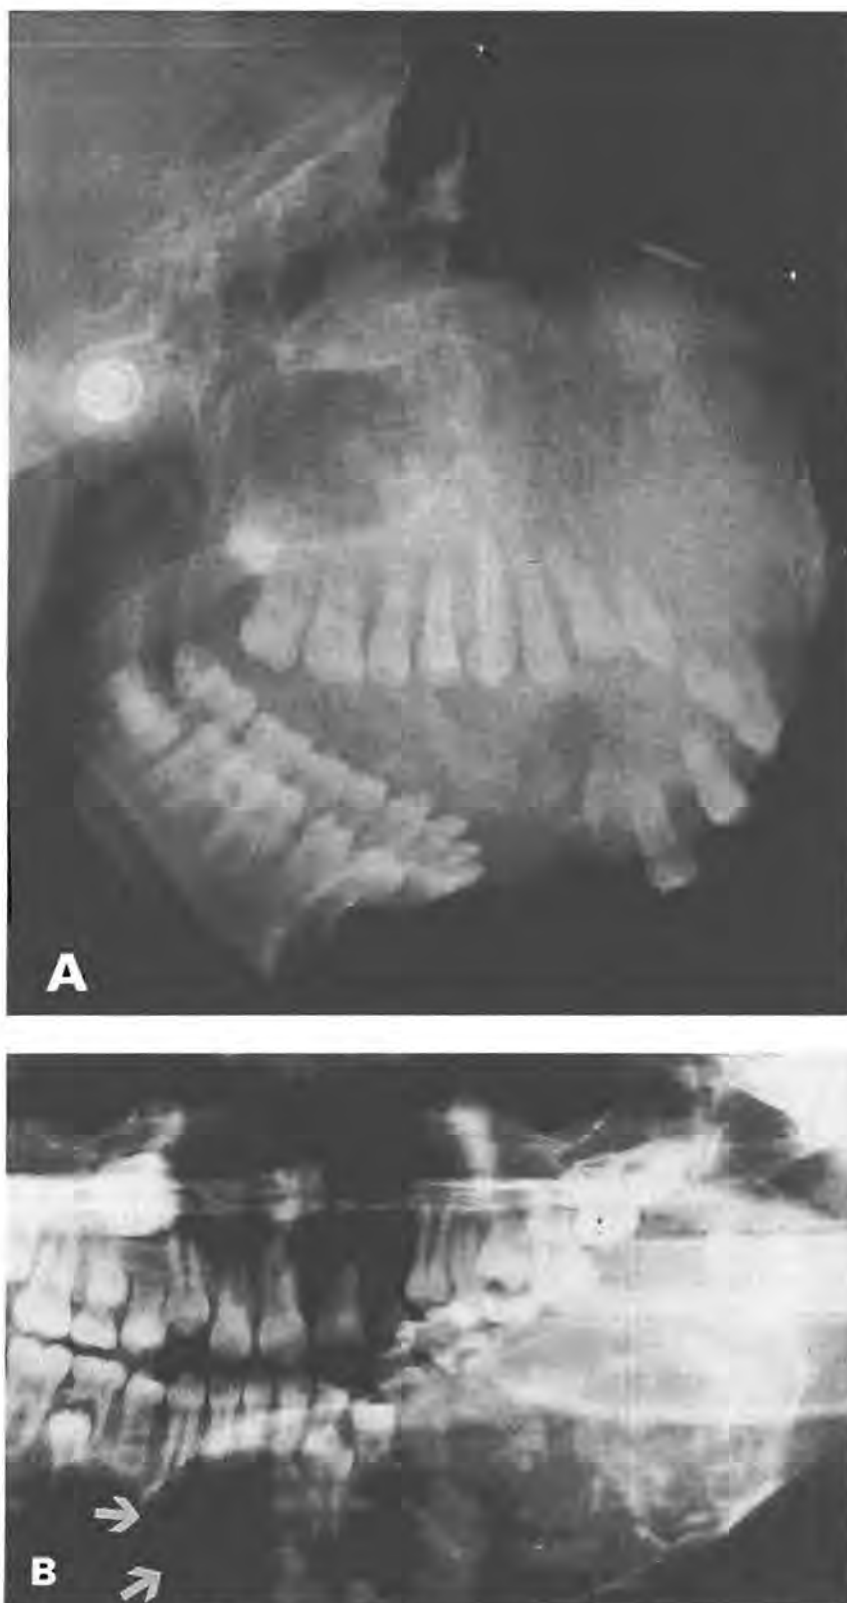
A, radiograph of Case 3 shows a well demarcated lesion with smokescreen appearance and irregular radiolucent areas. B, Prominent lytic areas are present in Case 1 (arrows).
